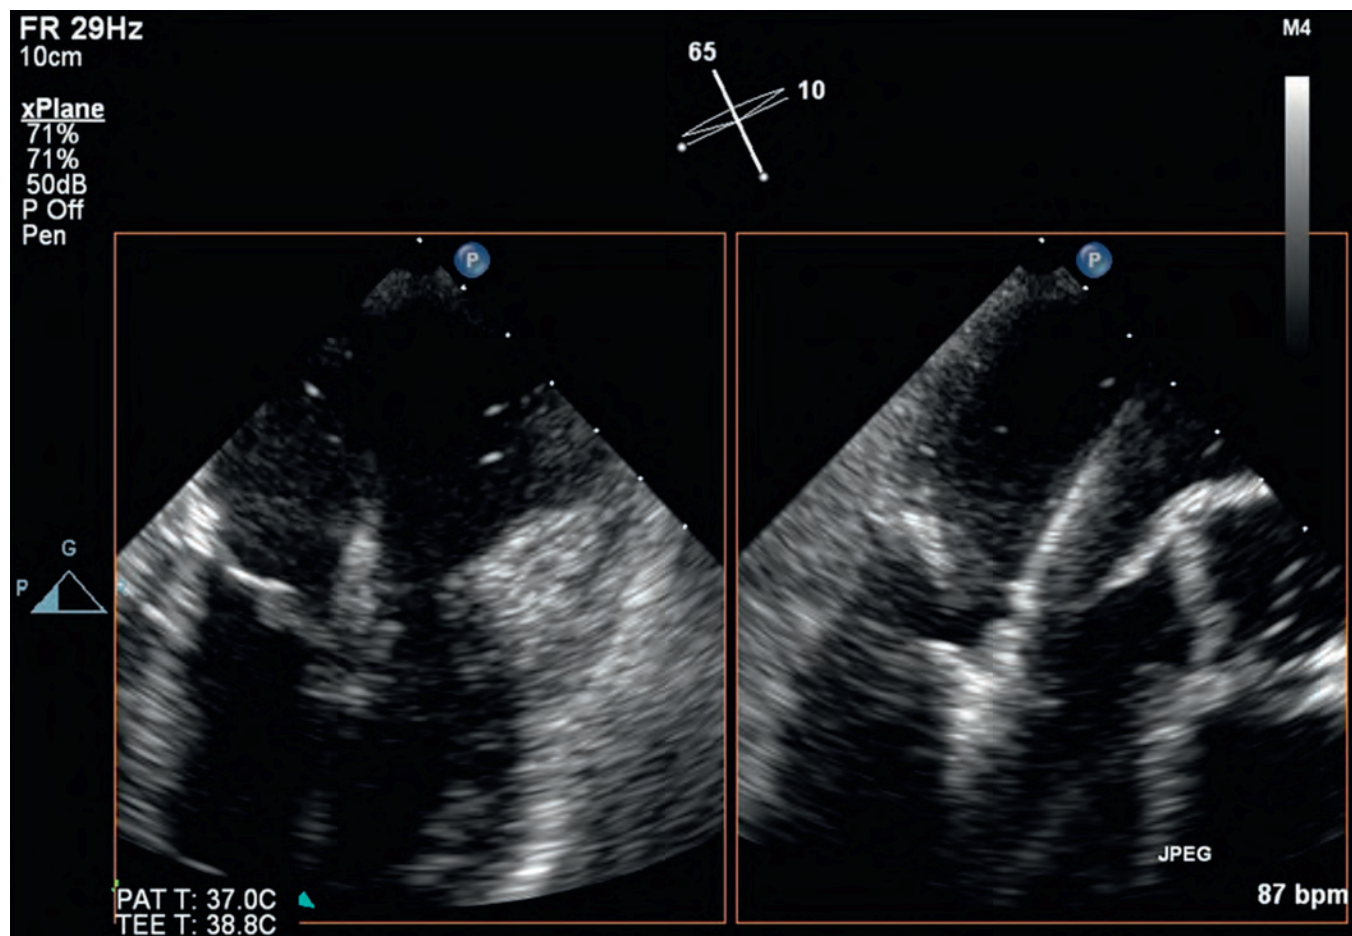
Echocardiographic image of MitraClip placement.
